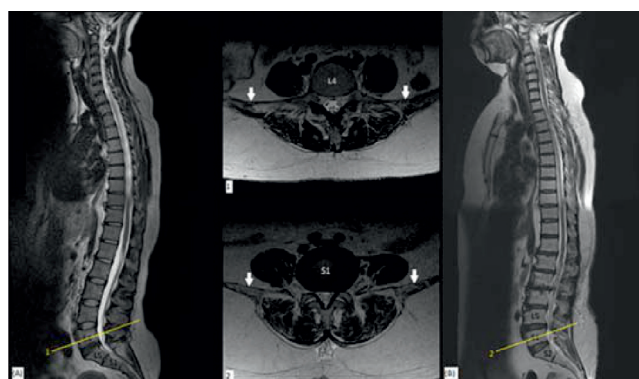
Clockwise - MRI images of (A) T2W mid sagittal section of LSTV spine with sacralization of L5 (Castellvi type 3b); (1) T2W axial section of spine shown in (A) at L4 showing bilateral ILL arising from L4; (B) T2W mid sagittal section of LSTV spine with complete lumbarization of S1; and (2) T2W axial section of spine shown in (B) at S1 showing bilateral ILL arising from S1.
